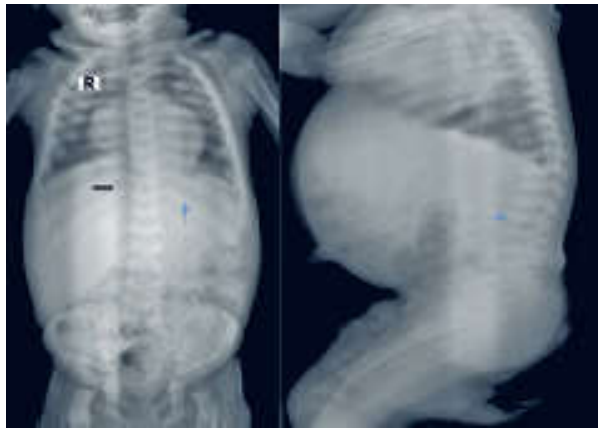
CXR A/P view showing oar shaped ribs with narrowing at the vertebral ends. X-ray dorso lumbar spine lateral view showing Rounded vertebral bodies with anterior beaking
